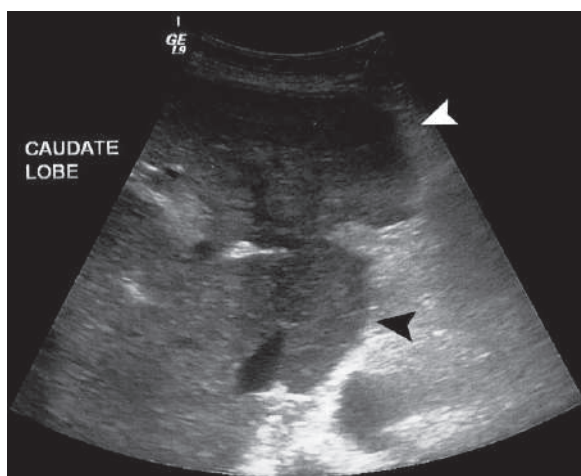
Transverse ultrasound image of a patient with liver cirrhosis shows atrophied left lobe (white arrowhead), with hypertrophied caudate lobe (black arrowhead)
